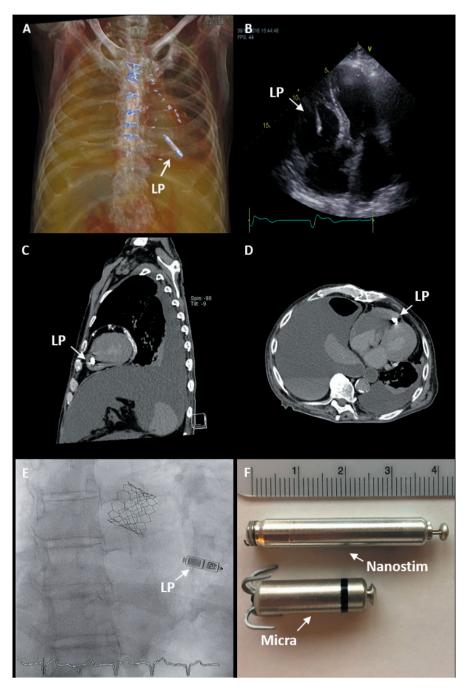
The Micra and Nanostim Leadless Pacemakers Leadless pacemaker therapy. Panel A: postmortem computed tomography (CT) with three-dimensional reconstruction of the Nanostim in the right ventricle. Panel B: transthoracic echocardiogram in apical 4-chamber view of the Nanostim in the right ventricle. Panel C: sagittal plane of a CT-scan of an in situ leadless pacemaker. Panel D: transverse plane of a CT-scan of an in situ leadless pacemaker. Panel D: transverse plane of a CT-scan of an in situ leadless pacemaker. Panel D: transverse plane of a CT-scan of an in situ leadless pacemaker. Panel E: radiogram of a Micra TPS after transcatheter aortic valve replacement. Panel F: photograph of the Nanostim LCP and Micra TPS.
